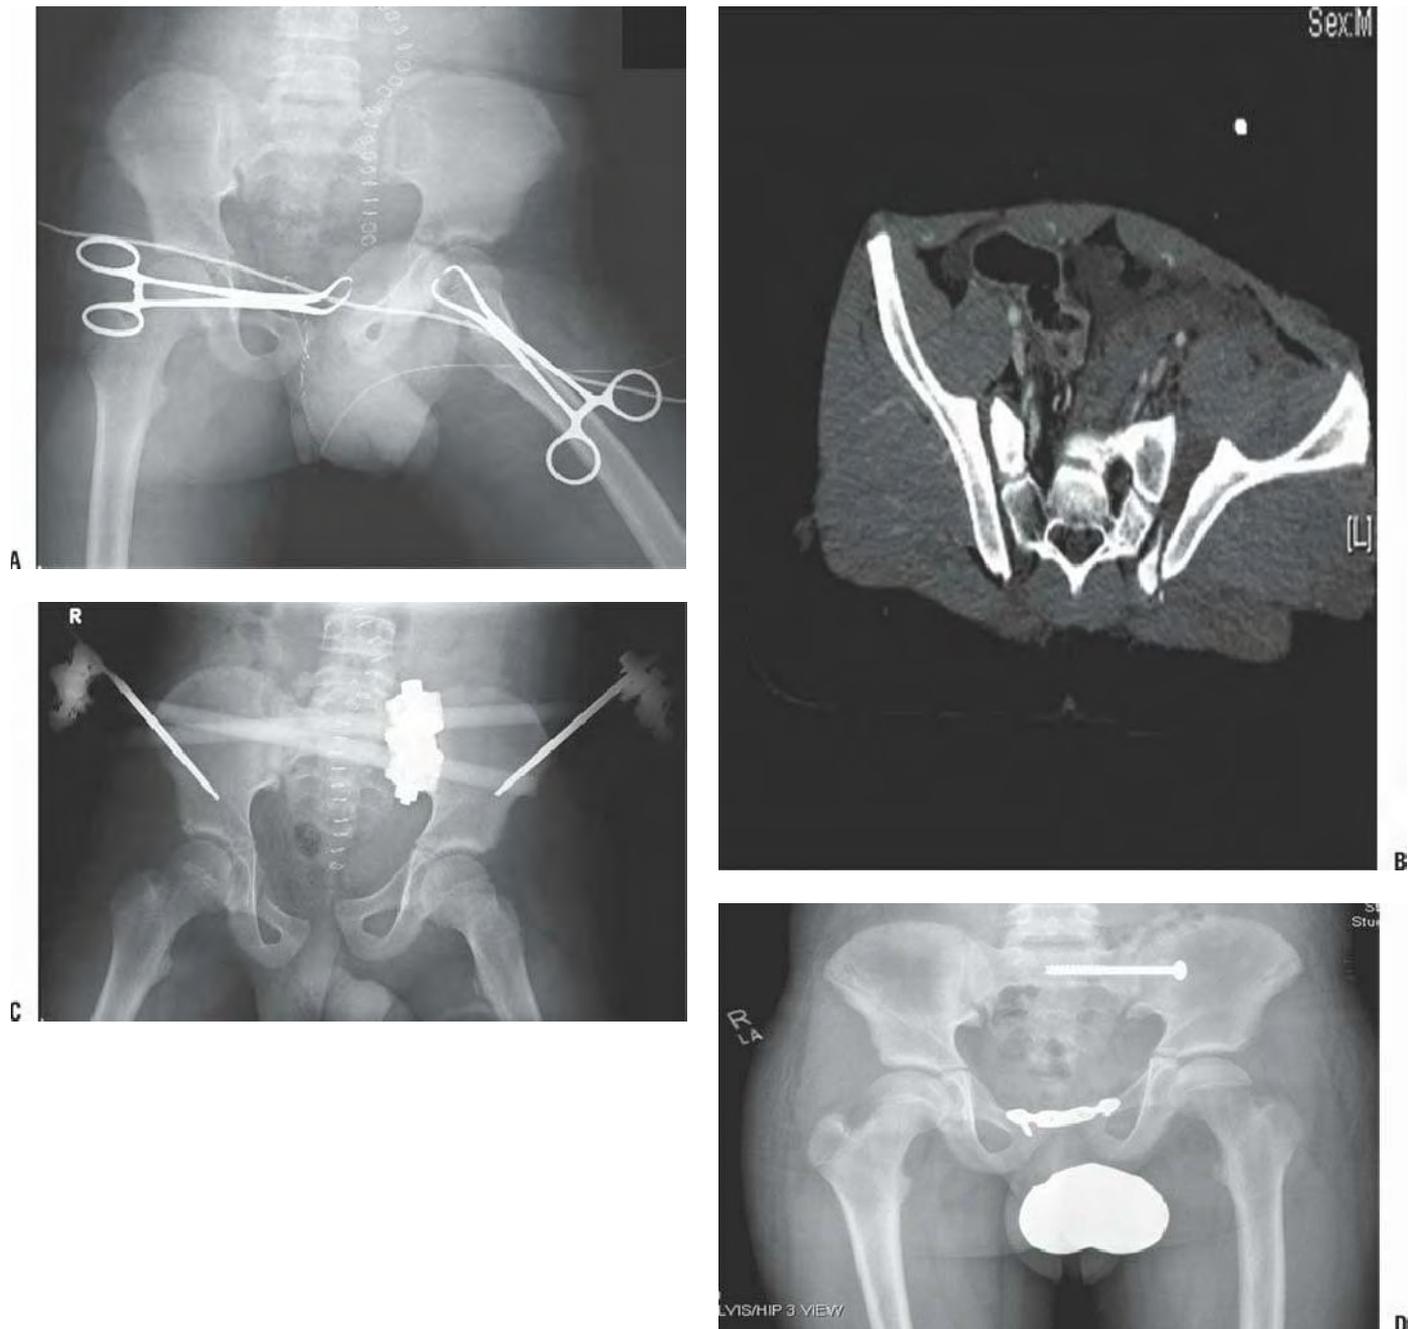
Radiograph (A) and CT scan (B) of a 12-year-old male with an unstable pelvic fracture. A pelvic band with a sheet was placed around the pelvis to temporarily improve hemostasis. C: An anterior external fixator was urgently placed to temporarily stabilize the pelvis and improve the hemodynamic status. D: Once the patient was stable, an anterior symphysis plate achieved anterior ring stabilization and an S1 sacroiliac screw was placed to achieve posterior stabilization. Some mild plastic deformation remains in the immature pelvis.
